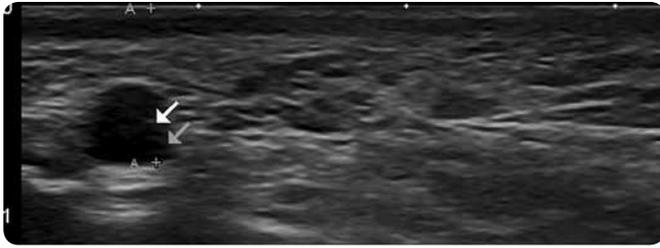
Ultrasound image characteristic of liquid silicone with oval, cystic, hypo-echoic images of well-defined edges (arrows).
